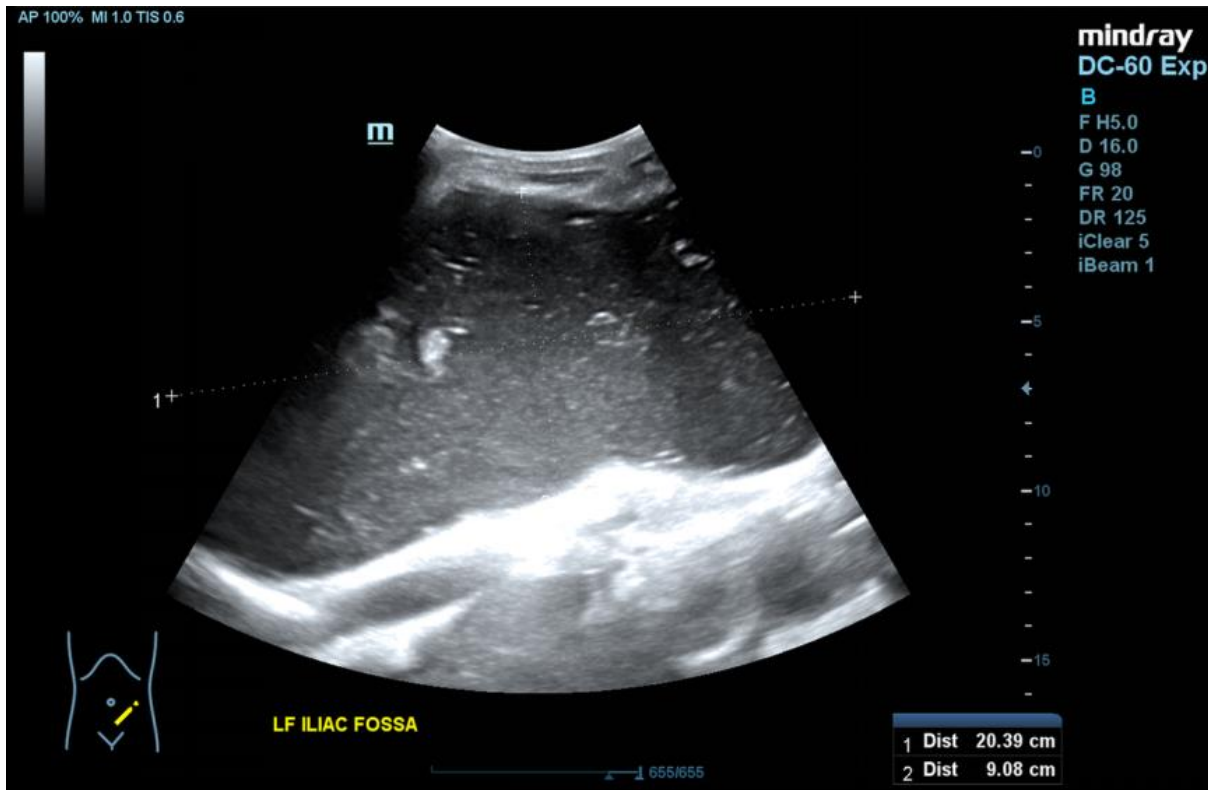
Abdomen ultrasound image showing dilated gastric cavity, which is fluid-filled, extending to just above the left iliac fossa.
